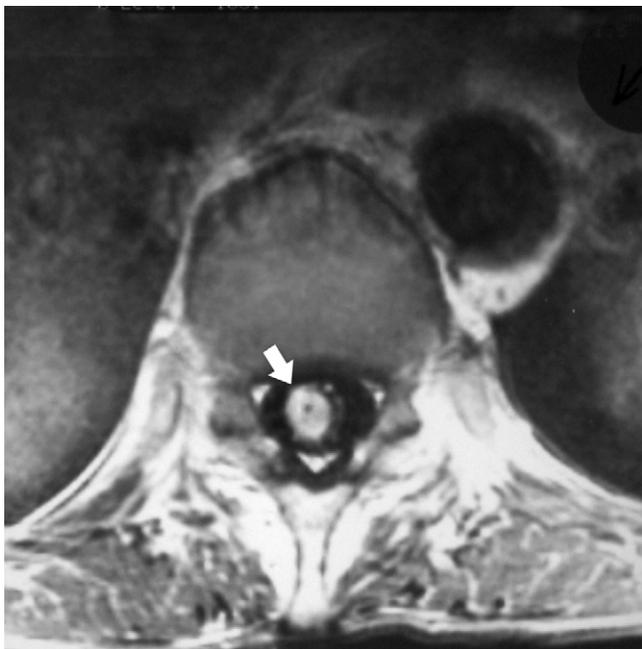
Intramedullary spinal cord *Histoplasma* granuloma. Axial T1-weighted image with gadolinium shows an enhancing granuloma within the substance of the thoracic cord (white arrow).
